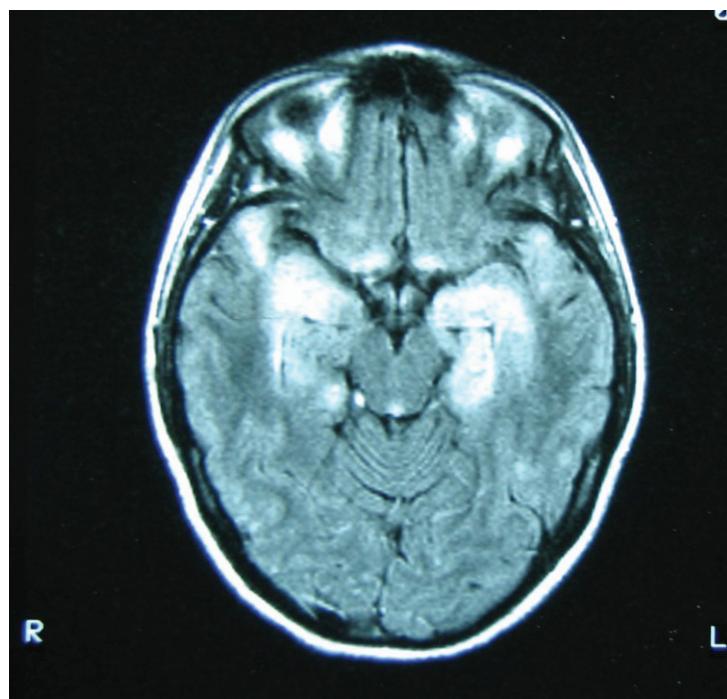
Initial MRI in FLAIR showed increased hyperintense signals in the medial part of both temporal lobe, insula and hippocampus.
